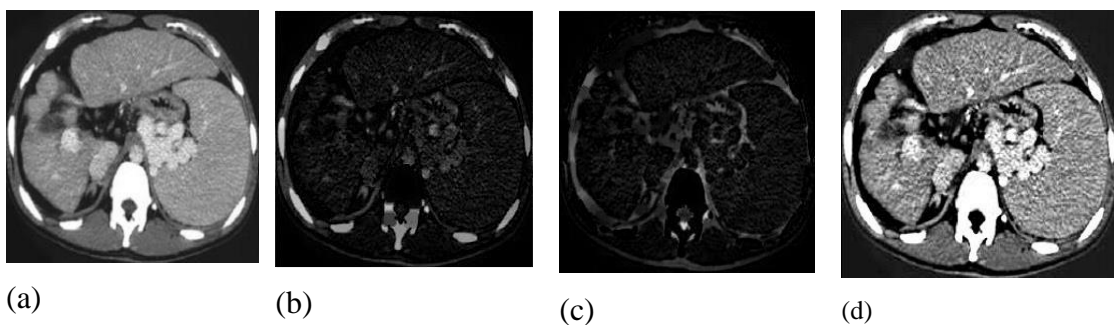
(a) Original test CT image (b) White top-hat transform output image (c) Black top-hat transform output image (d) Enhancement output dependent on (b) and (c)
